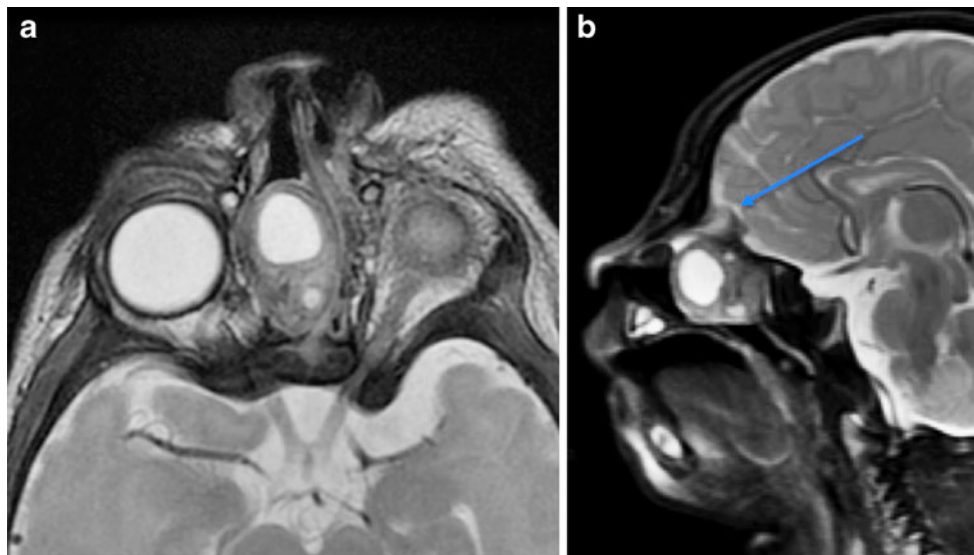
MRI coronal (a), sagittal (b) and axial (c) T2-W sequences show areas of T2 hypointensity that correspond with coarse calcifications visualized on CT. Other areas of T2 hypointensity reflect fibrosis. Areas of well-defined T2 hyperintensity, reflecting cystic and myxoid components CT (yellow arrow), are much more clearly defined than the corresponding low-density regions on CT. Coronal T2 and sagittal fat-saturated T2-W sequences (a, b) better demonstrate intracranial extension through the non-ossified cribriform plate. The mass is extradural and extends through the floor of the anterior cranial fossa, displacing the frontal lobe superiorly, with a thin rim of T2 hyperintense CSF separating the dural mass component from the brain parenchyma (blue arrows). Intraorbital extension through the medial left orbital wall causes mass effect upon the posterior left orbital contents and apex (red arrow). d A post-contrast coronal T1-W image demonstrates variable but mild enhancement
